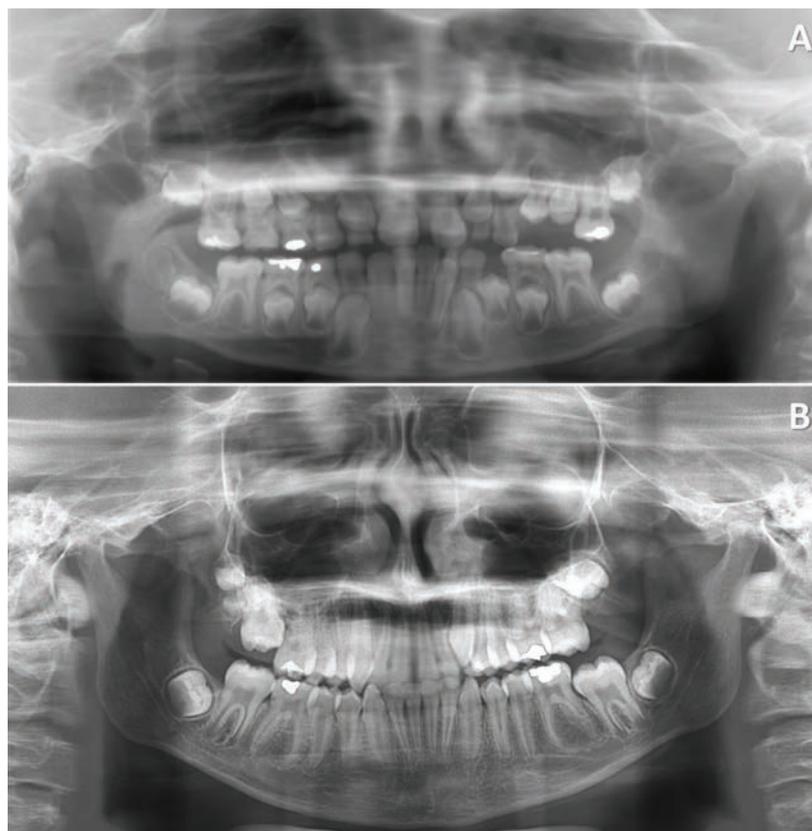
(A) Patient at 7-year-old, initial radiographic examination. (B) Patient at 11-year-old, actual radiographic examination.
